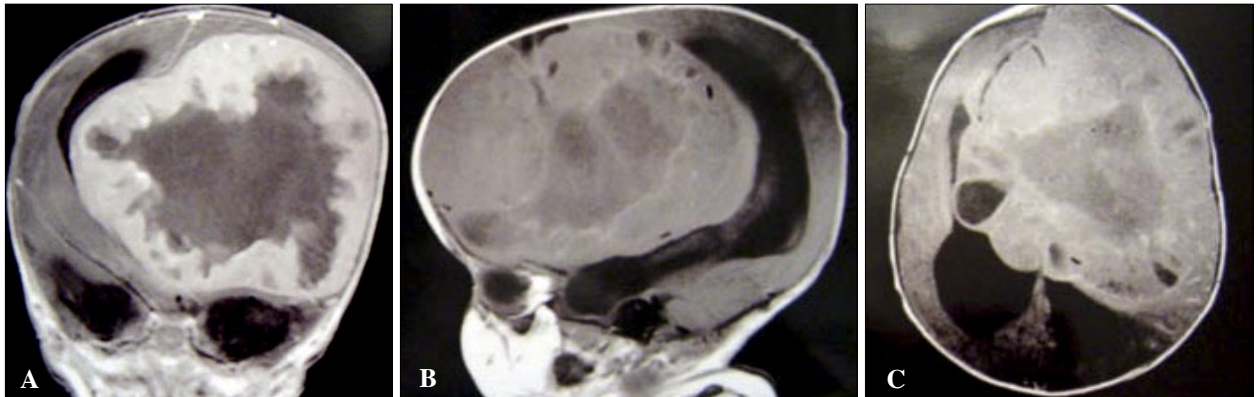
Post-contrast T1-weighted coronal (A), sagittal (B) and axial (C) magnetic resonance images showing the extension of huge intracranial mass occupying 76.19% of the intracranial cavity and the distortion and compression of neural structures.
